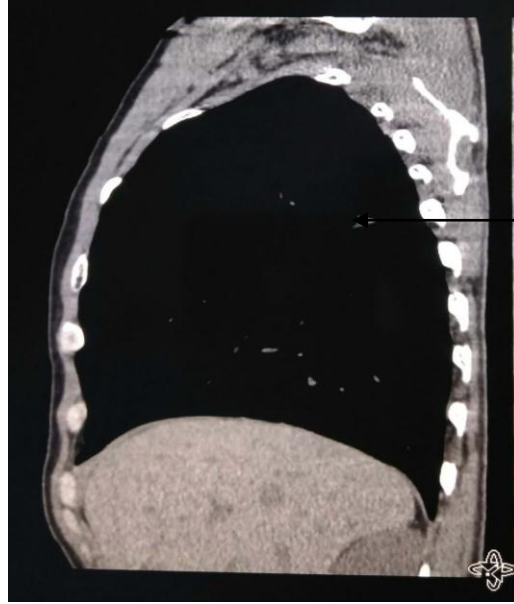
Sagittal view of chest CT showing ill-defined nodule with ground glass appearance in the posterior lower part of upper lobe of right lung.
